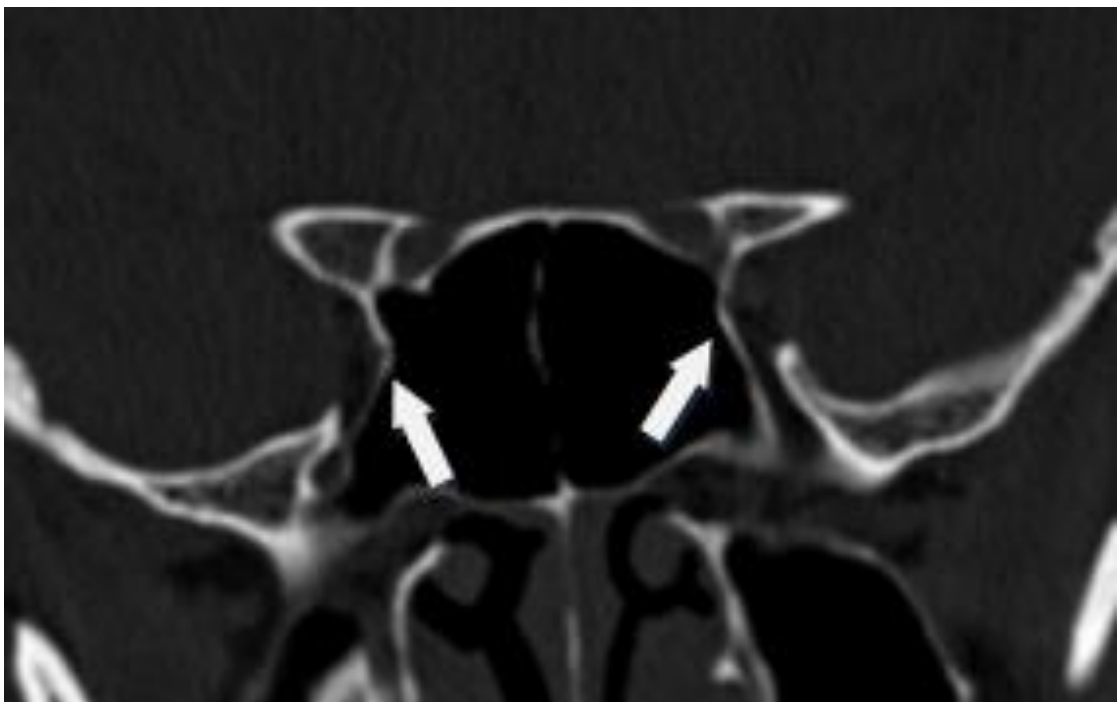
CT coronal section of sphenoid sinus showing protrusion of internal carotid artery. (arrows)
